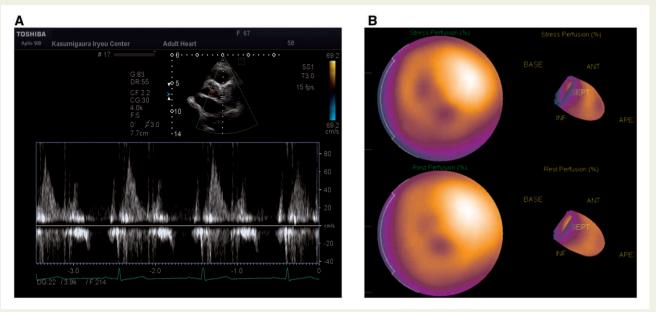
(A) Coronary flow velocity by Doppler echocardiography demonstrated a dominant systolic component at the left main coronary trunk. (B) Polar mapping of adenosine triphosphate stress myocardial perfusion scintigraphy identified reversible perfusion defects in the anterior wall.
